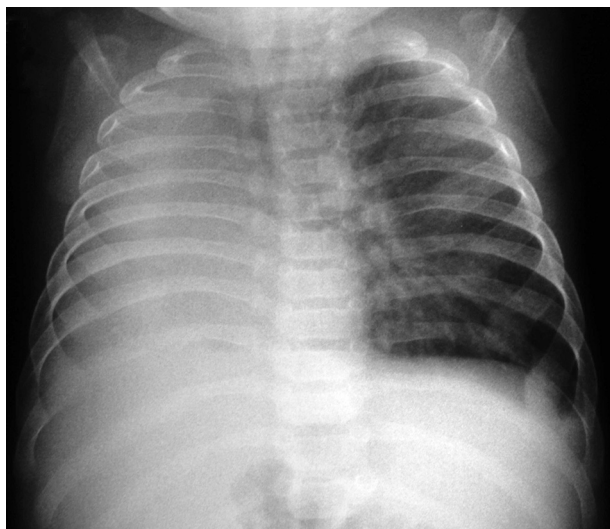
Chest x-ray showing a complete opacity of the right lung with mild mediastinal shift toward the affected side.
